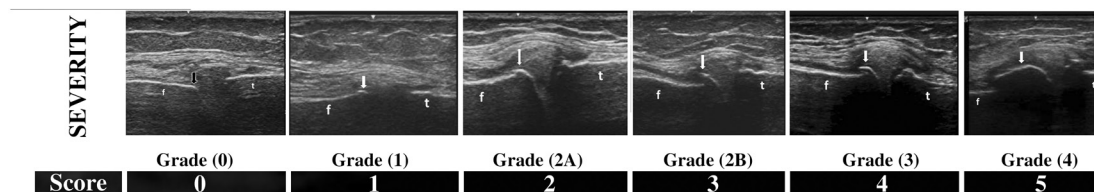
Different grades of severity of knee osteoarthritis by ultrasonography according to the shape of medial femoral osteophytes. White arrow, medial femoral osteophyte. f; femur, t; tibia.
